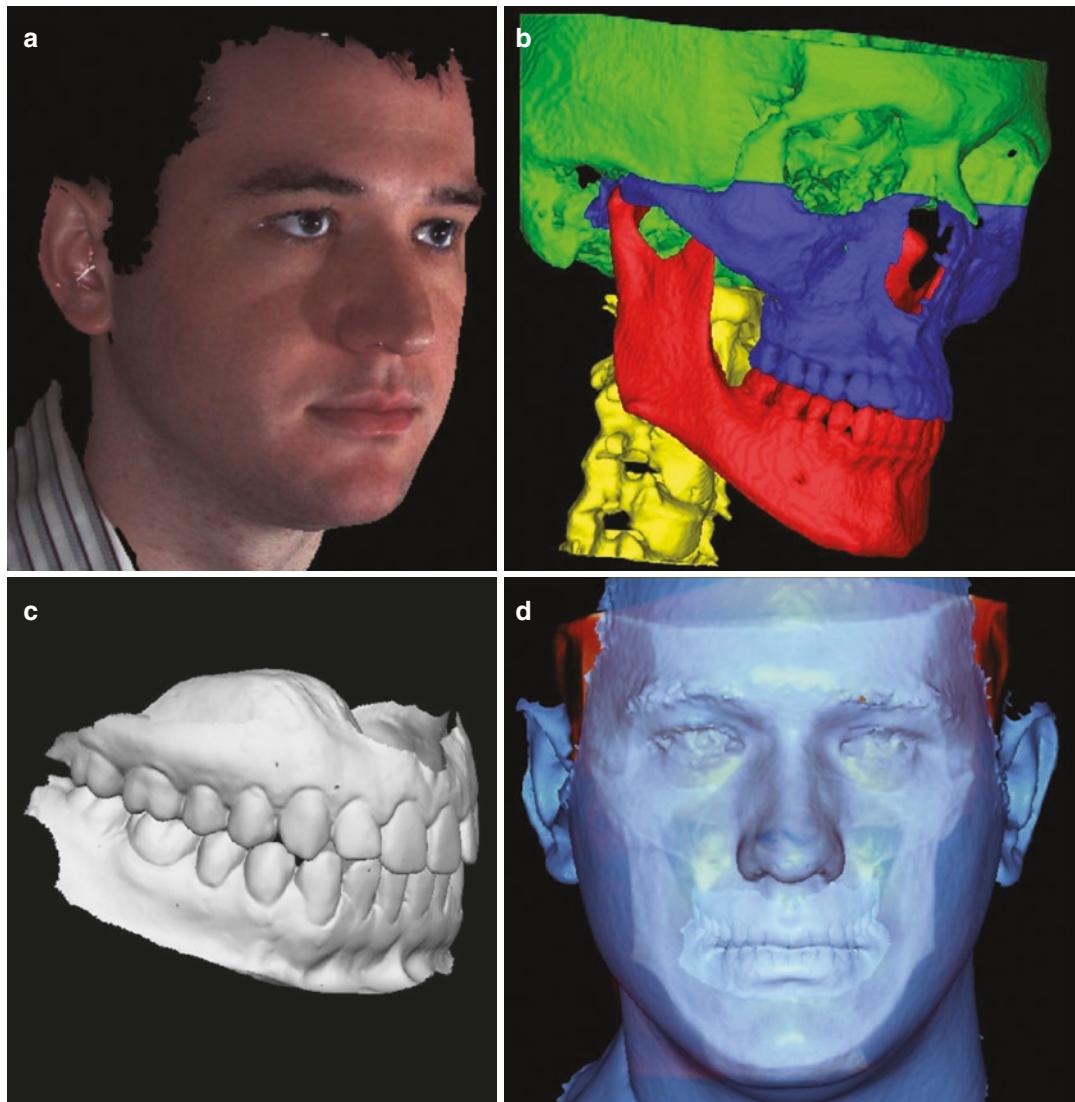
(a) 3D stereolithographic photo, (b) CBCT scan reconstruction, (c) scanned model of the teeth in occlusion, and (d) superimposition of the three images
